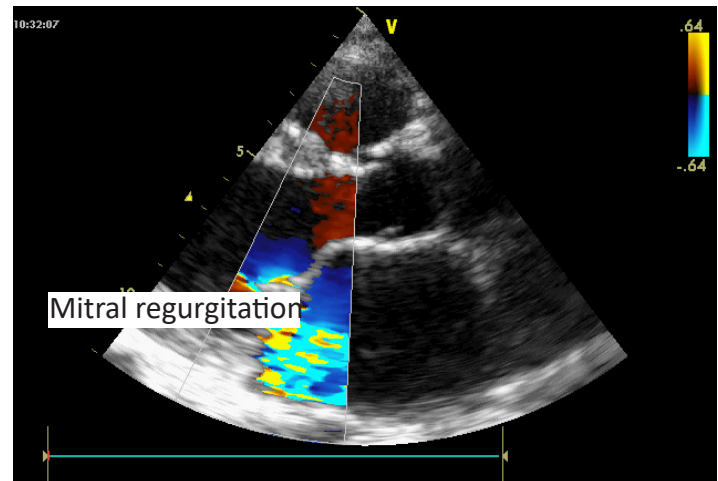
Long axis parasternal transthoracic echocardiography with eccentric mitral regurgitation (blue arrow).
